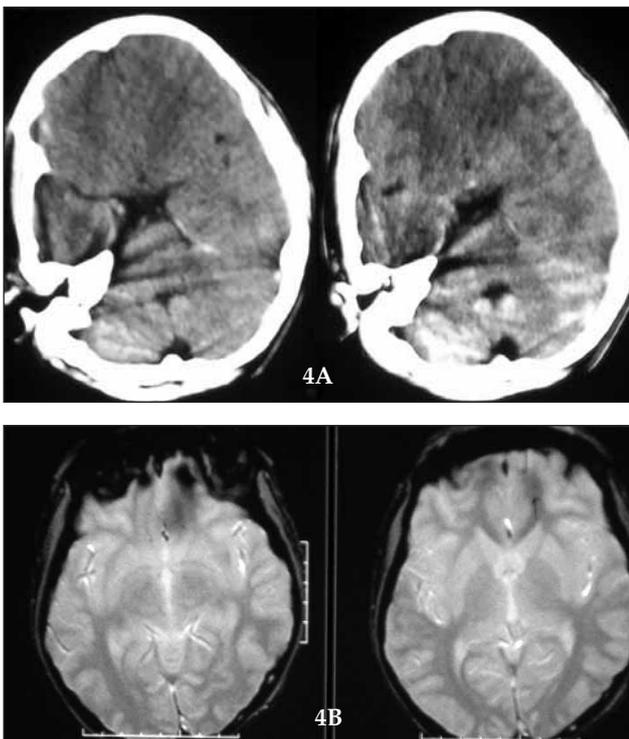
(A) Posttraumatic computed tomography show a normal appearance of frontobasal region. (B) A left side hypointense posttraumatic gray mater lesion observed in proton density slices.
